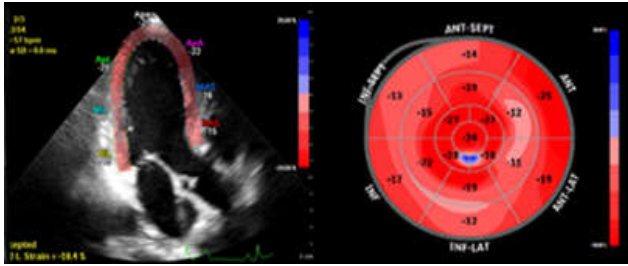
Echocardiographic evaluation by two dimensional speckle tracking analysis.
